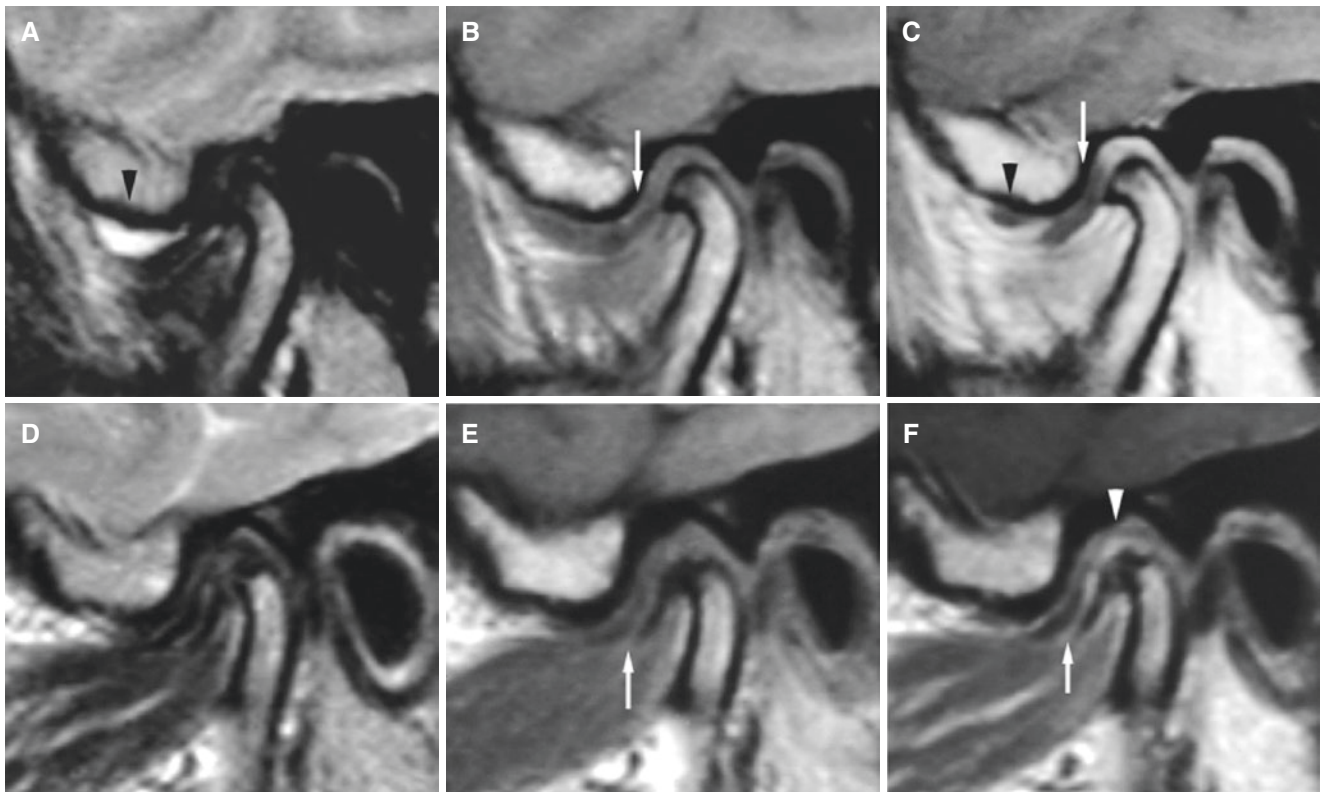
Rheumatoid arthritis, disc displacement of the right (A, B, C) and left (D, E, F) joint. (A) Oblique sagittal T2-weighted MRI shows effusion in anterior recess of the upper compartment (*arrowhead*). (B) Oblique sagittal T1-weighted pre-Gd and (C) oblique sagittal T1-weighted post-Gd MRI show anteriorly displaced disc (*arrow*) and contrast enhancement in peripheral rim of effusion (*arrowhead*) and in posterior attachment, consistent with thickened synovium. Secondary osteoarthritis. (D) Oblique sagittal T2-weighted MRI shows no fluid. (E) Oblique sagittal T1-weighted pre-Gd and (F) oblique sagittal T1-weighted post-Gd MRI show anteriorly displaced disc (*arrow*) and slight contrast enhancement in joint space above the condyle (*arrowhead*), consistent with thickened synovium. Secondary osteoarthritis
